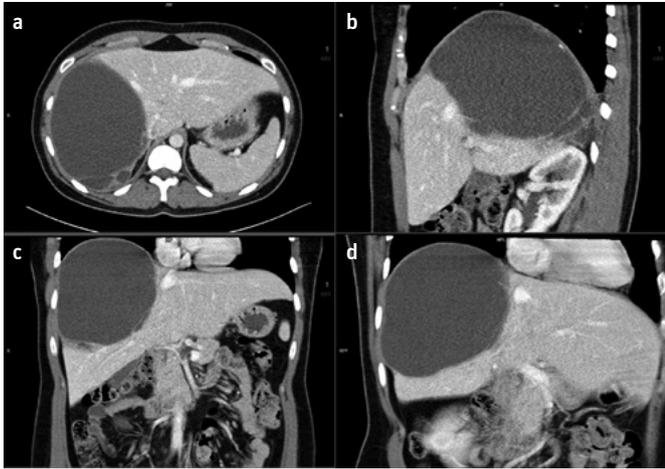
a-d. Large biliary cystadenoma of the right liver lobe—multiple detector computed tomography (MDCT); (a) axial, (b), sagittal, (c) coronal, (d) oblique reconstructions
